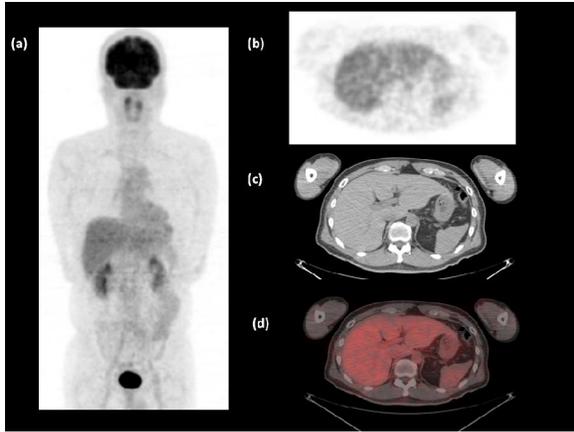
A 55-year-old male with a heterogeneous pattern on the 18F-FDG-PET/CT image of the liver. (a) PET volume image, (b) PET cross-section image, (c) CT images, and (d) fusion PET/CT image. Window level and width are same as Figure 1.
